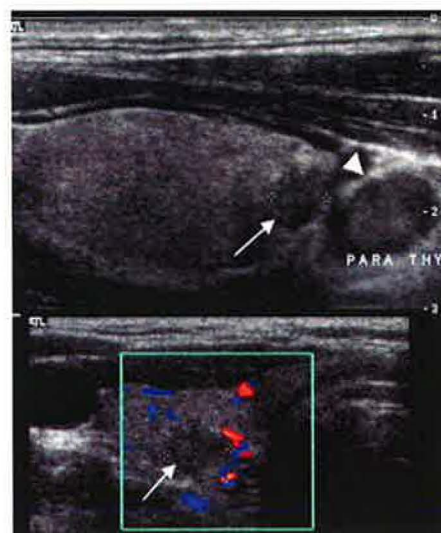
Incidentally discovered 6 mm papillary thyroid cancer found on US performed for parathyroid adenoma. Top panel; sagittal view w nodule (thin arrow). Bottom panel: color flow Doppler shows increased vascularity in nodule (from ref 6)
